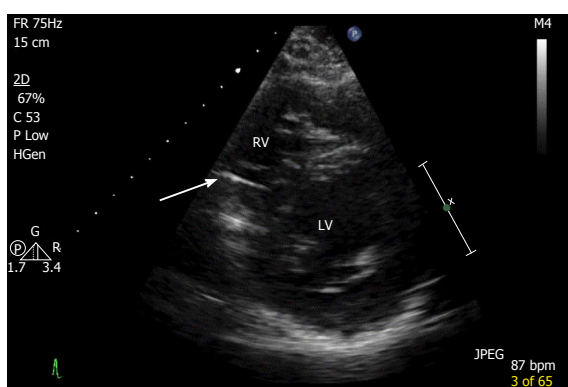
Echocardiography short axis view showing liner foreign body in the right ventricle.
